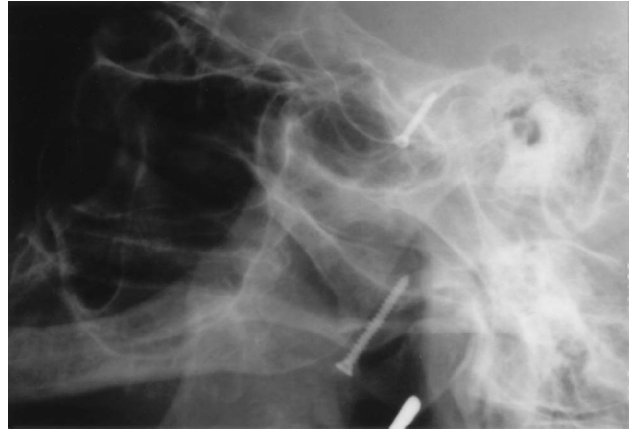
Lateral radiograph shows the relation of the condyle and screw.
